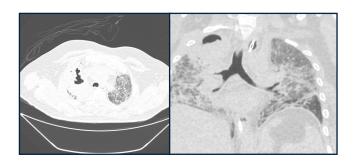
Chest computed tomography in axial and coronal view with necrotizing pneumonia.
